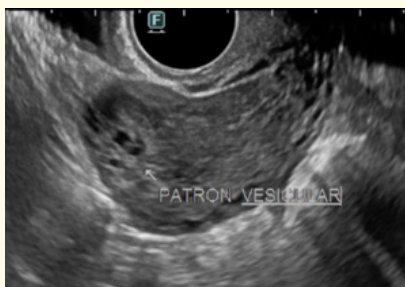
Endo vaginal ultrasound showing myometrium in the uterine fundus with a vesicular pattern.
